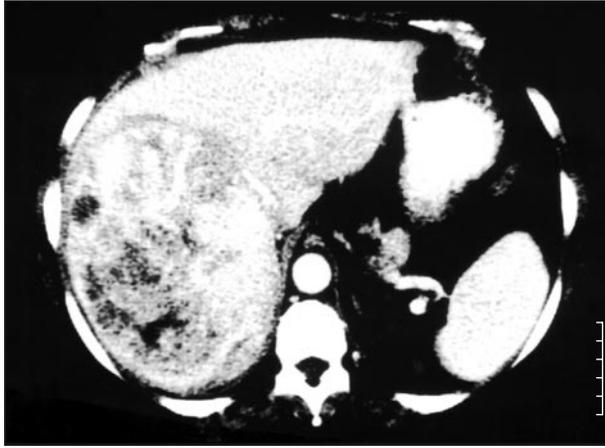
Computed tomographic image of a hepatic tumor with intralesional hemorrhage and necrosis, typical features of a hepatocellular adenoma. This tumor was resected because of its large diameter.
